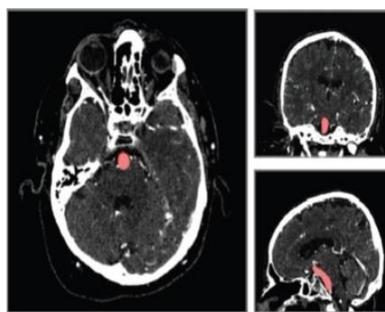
Computed tomography angiography image of brain with cerebral aneurysm
